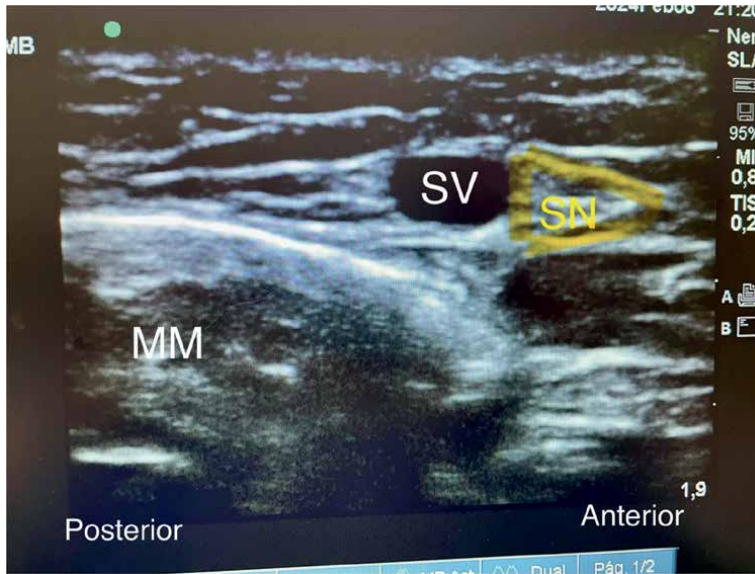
Sonography of the saphenous nerve (SN) at the level of medial malleolus. It lies within the same fascia plane with the greater saphenous vein (SV). Source: Author.
